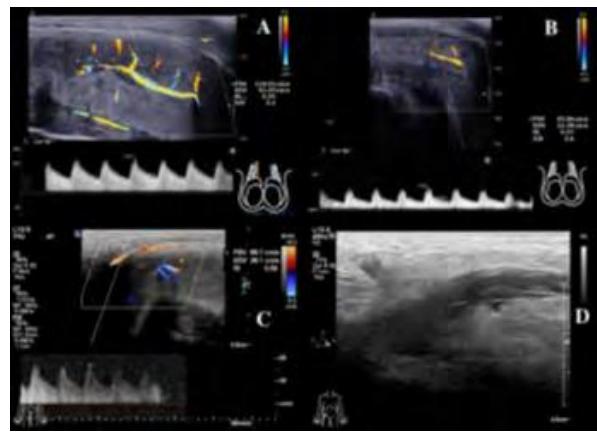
Color doppler ultrasound images of the penis. A. Blood flow spectrum of the right penile cavernous artery, resistance index (RI)=0.55. B. Blood flow spectrum of the left penile cavernous artery, RI=0.57. C. Blood flow spectrum of penile dorsal artery, RI=0.59. D. The mural thrombus of the right saphenofemoral junction.
